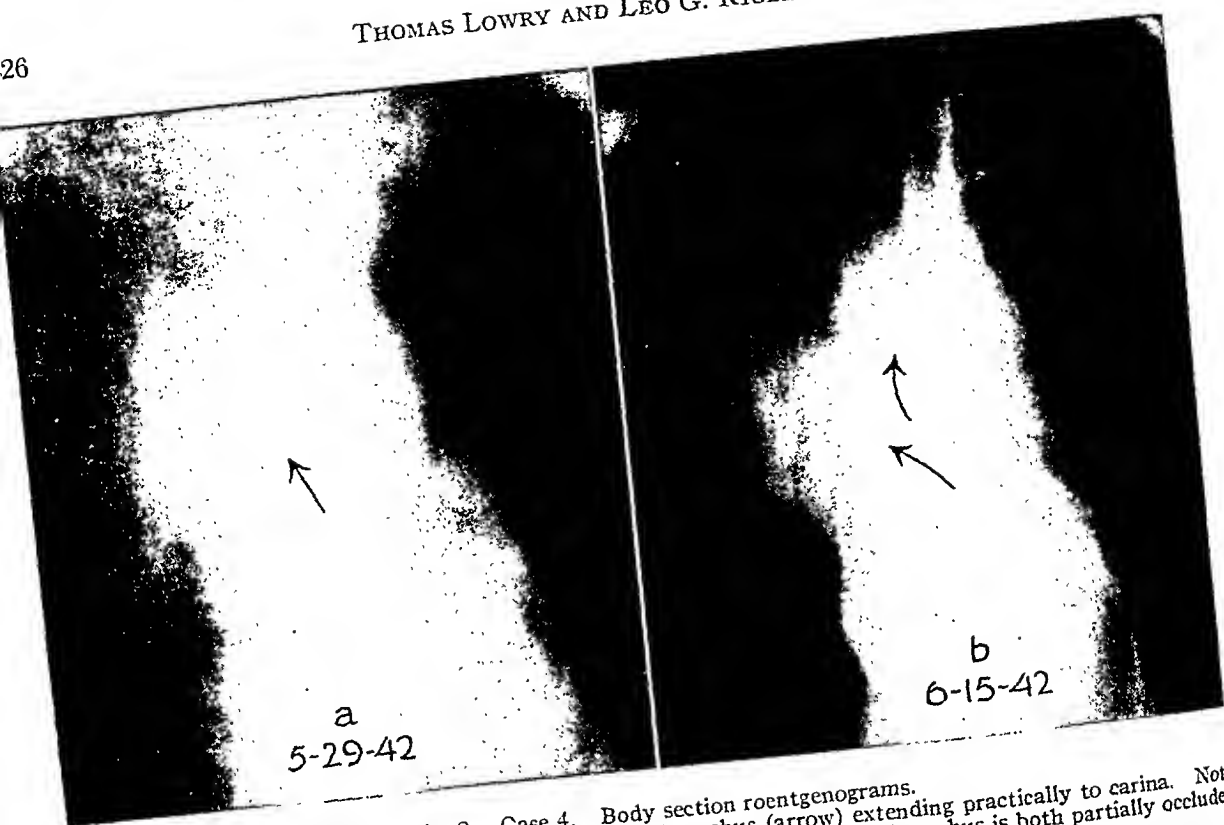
Case 4. Body section roentgenograms.
